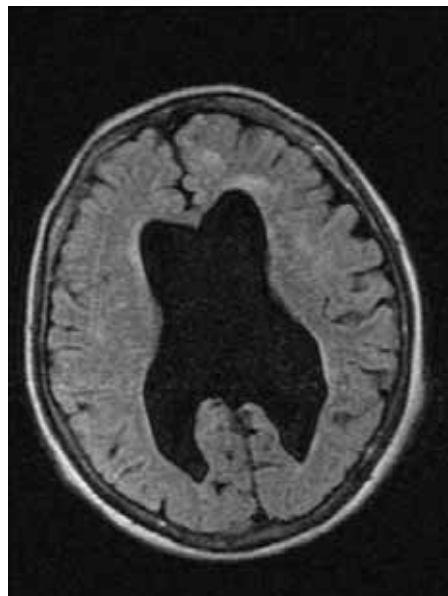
Cerebral MRI – internal hydrocephalus
